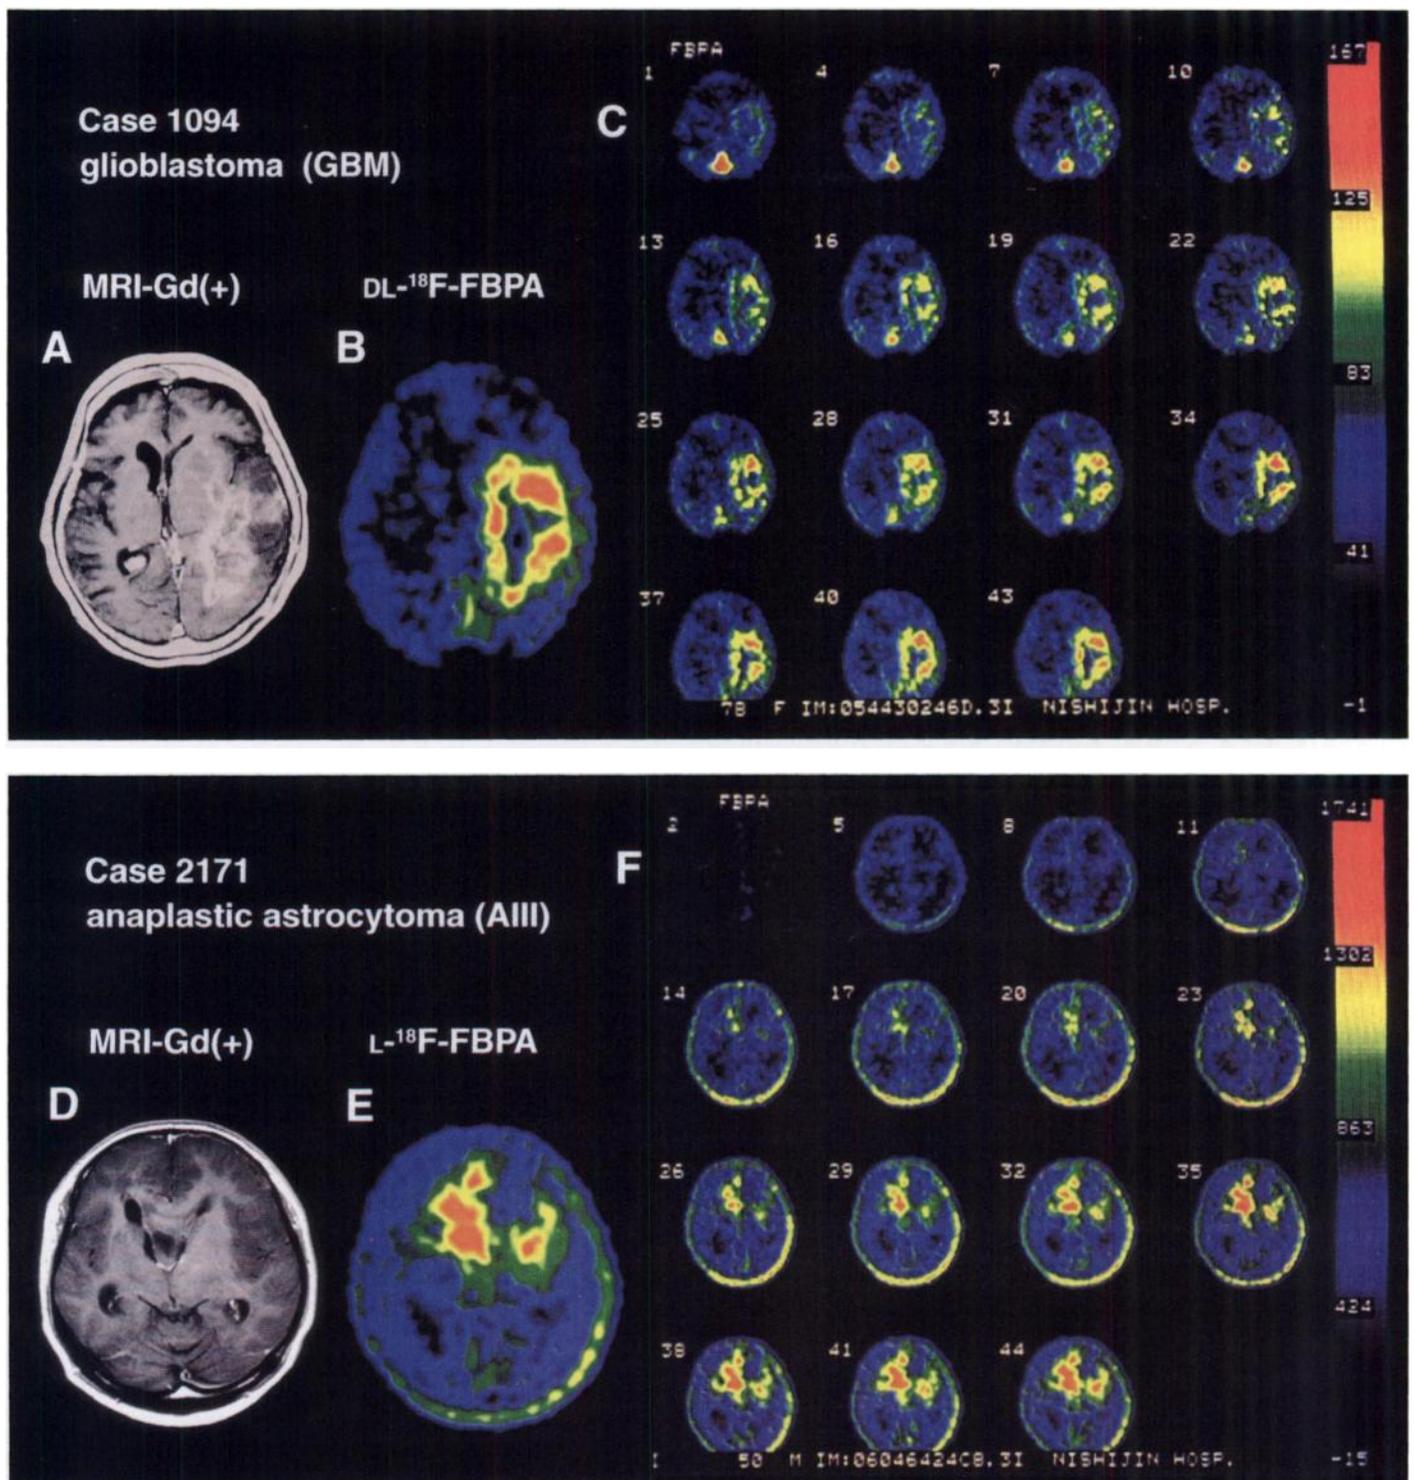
Typical PET images of ^{18}F - ^{10}B -FBPA in patients with gliomas. Typical dynamic PET studies using DL- and L- ^{18}F - ^{10}B -FBPA in patients with glioblastoma (A–C, Case 1094) and anaplastic astrocytoma (D–F, Case 2171) are shown. (A and D) MRI with Gd enhancement. (B and E) PET images corresponding to the MRI. (C and F) Dynamic PET study using ^{18}F - ^{10}B -FBPA in patients with gliomas. A sequential scanning was performed nine times at 2-min intervals and six times at 4-min intervals. The total examination took 42 min.
